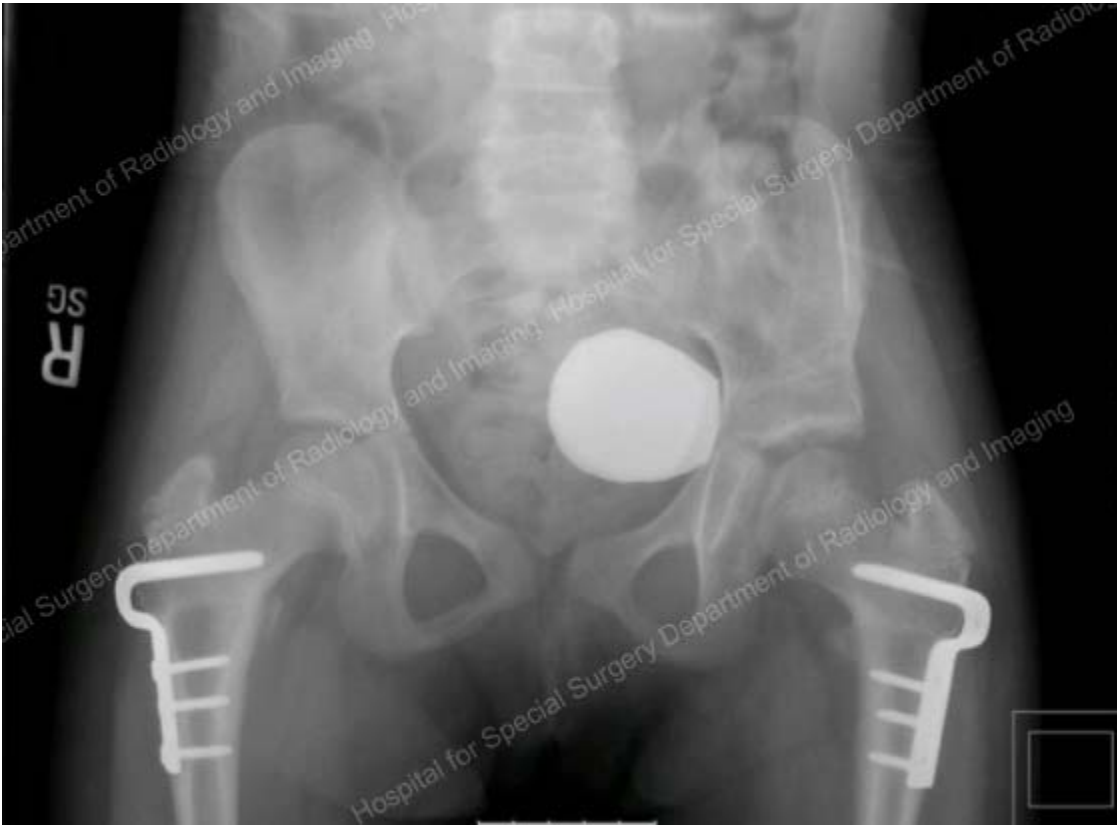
Post operative AP x-ray obtained 1 year post left pelvic osteotomy and bilateral VRO demonstrating that both hips are located.
